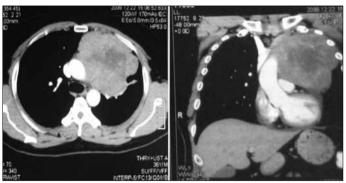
CT images of a heterogeneous hypodense mass in mediastinum which compresses left superior pulmonary vein
